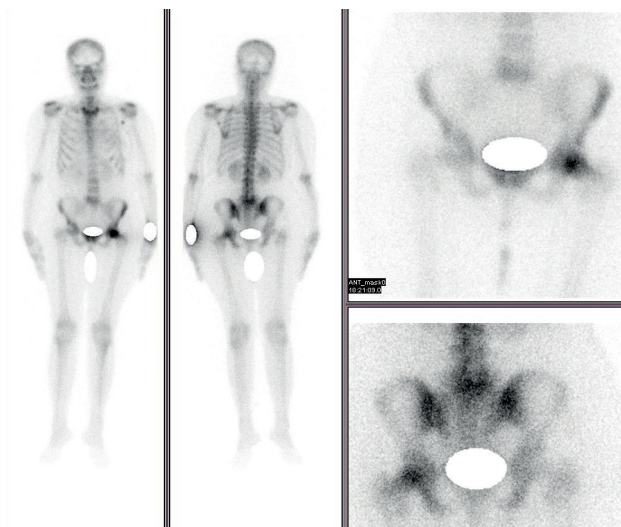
^{99m}Tc-MDP Bone scintigraphy showing focal increased uptake in the head of left femur with suspicion of AVN left head of femur.
